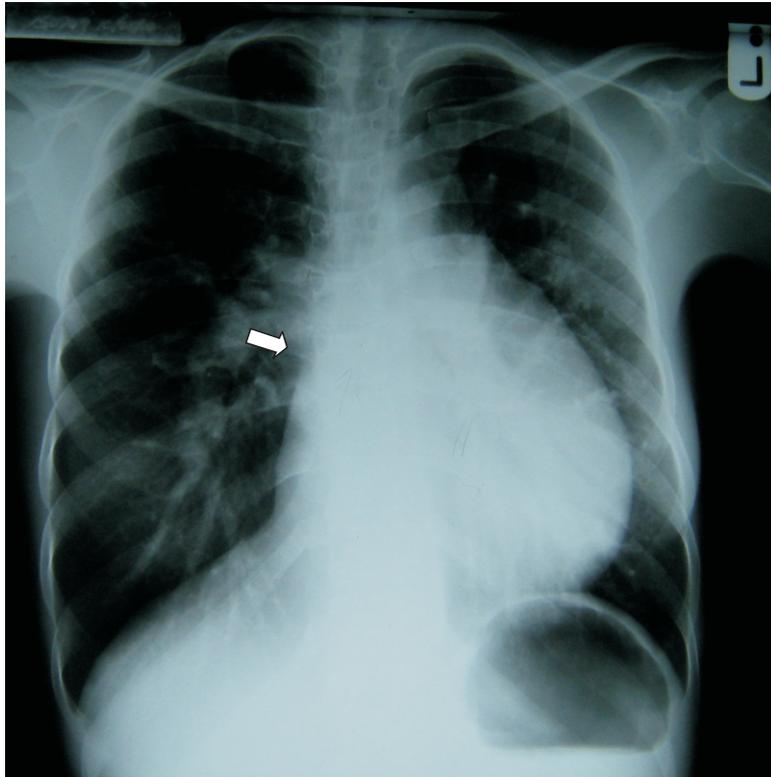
Postero-anterior chest radiograph showing cardiomegaly with rounding of the cardiac apex. Note prominence of the right pulmonary trunk (white arrow).
